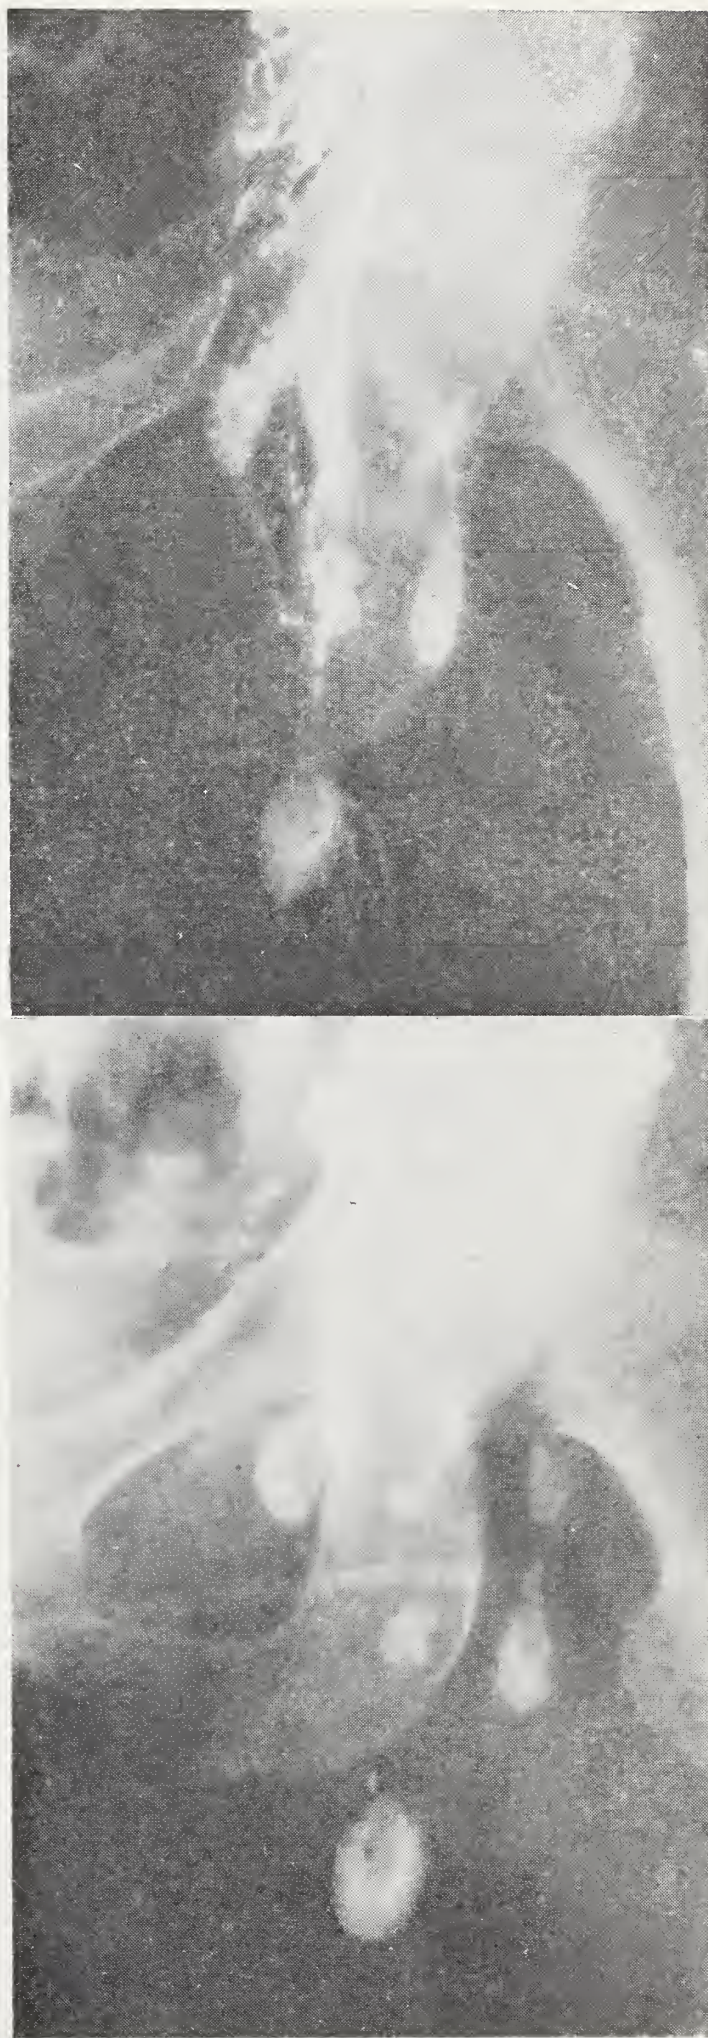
A) Normal individual nodes with lymphatic vessels; B) normal nodes (24 hour roentgenogram.) Notice the hilar region of inferior node showing a radiolucent filling defect.
